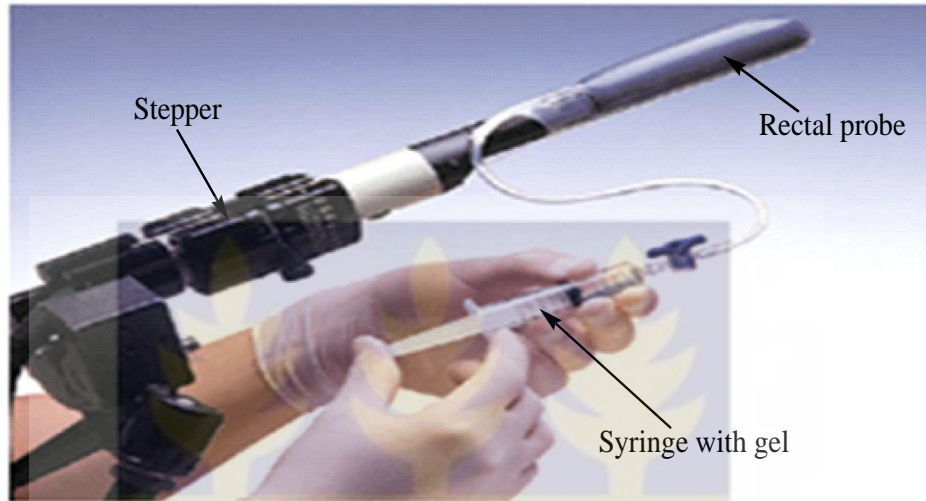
Ultrasound probe with contrast used during volume study
